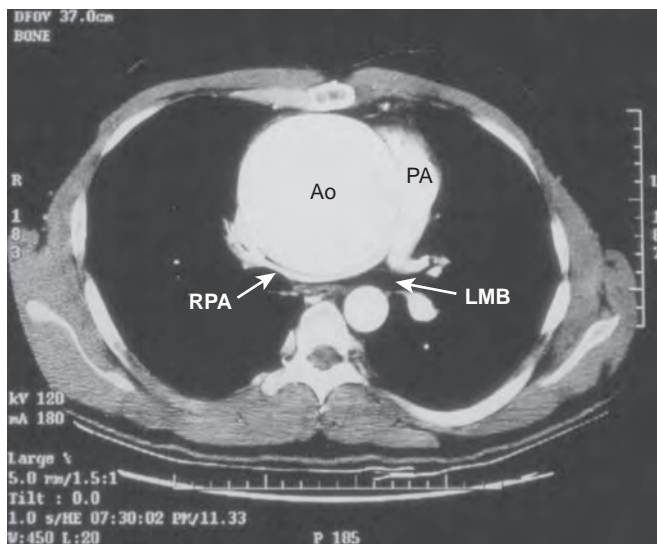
Computed tomographic angiogram of the chest demonstrating a large ascending aortic aneurysm (Ao) causing compression of the right pulmonary artery (RPA), distal trachea, and left main stem bronchus (LMB).
